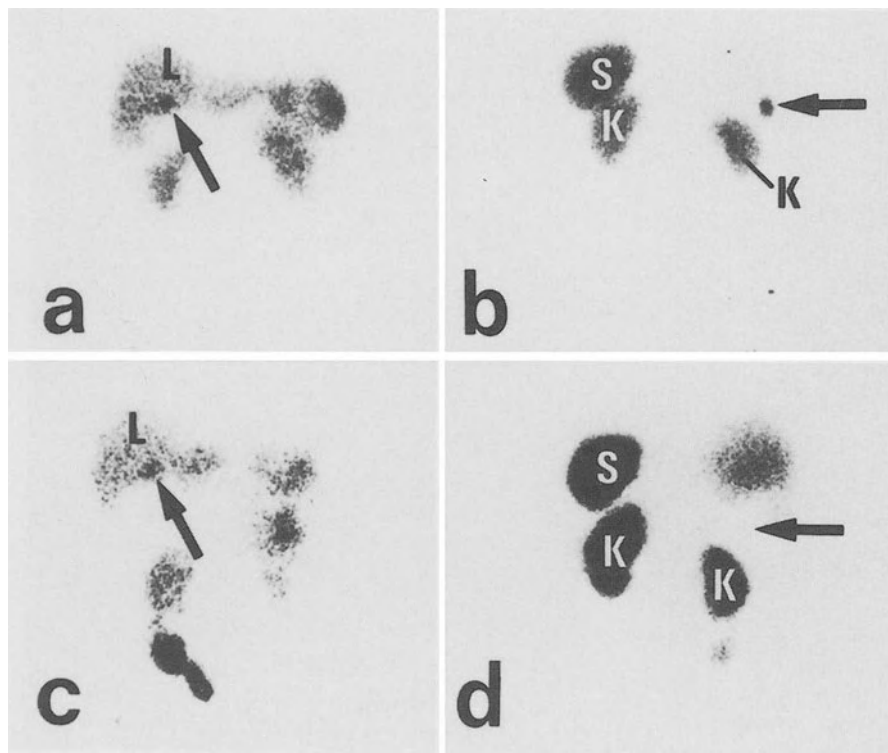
Anterior (a) and posterior (b) scintigraphic view before operation. *Arrow* shows ventral metastasis in (a) and dorsal metastasis in (b). *L*, liver. c Anterior view postoperatively still shows ventral metastasis (*arrow*). d Posterior view after operation no longer shows uptake where metastasis was removed (*arrow*)
